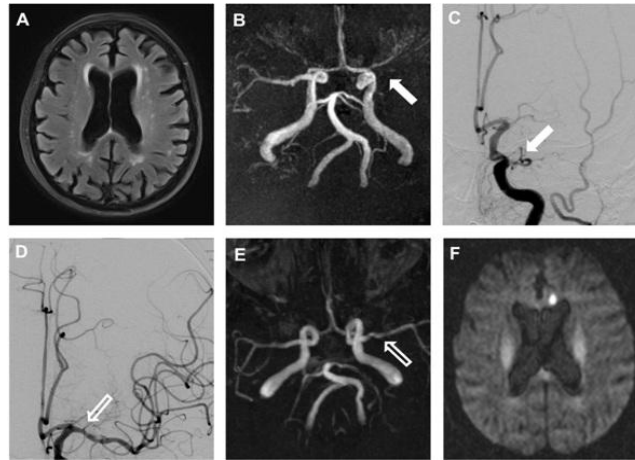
Magnetic resonance imaging (MRI, 3.0 T, Trio, Siemens, Germany) of the brain (different sequences) and DSA of the brain-perfusing vessels before and after mechanical thrombectomy (MT).
